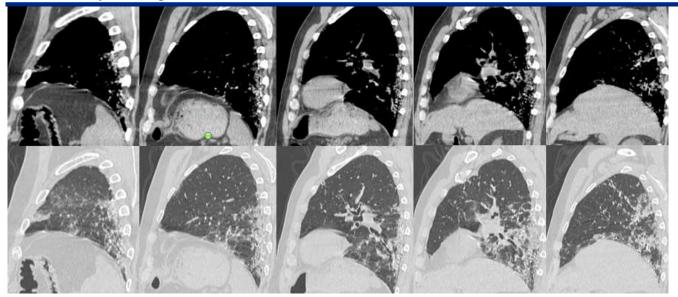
sagital thin-section unenhanced baseline CT scan showed bilateral and patchy consolidation with a prominent peripherally subpleural distribution, and preferred posterior and lower lobe.
